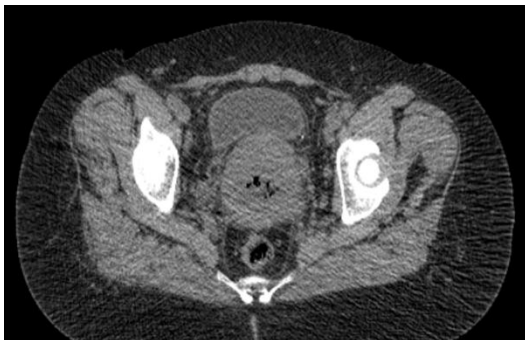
Computed tomography of the patient L. 1960: enlarged supravaginal part of the cervix, not pronounced deformation of the posterior wall of the bladder; external and internal inguinal lymph nodes are visualized.
